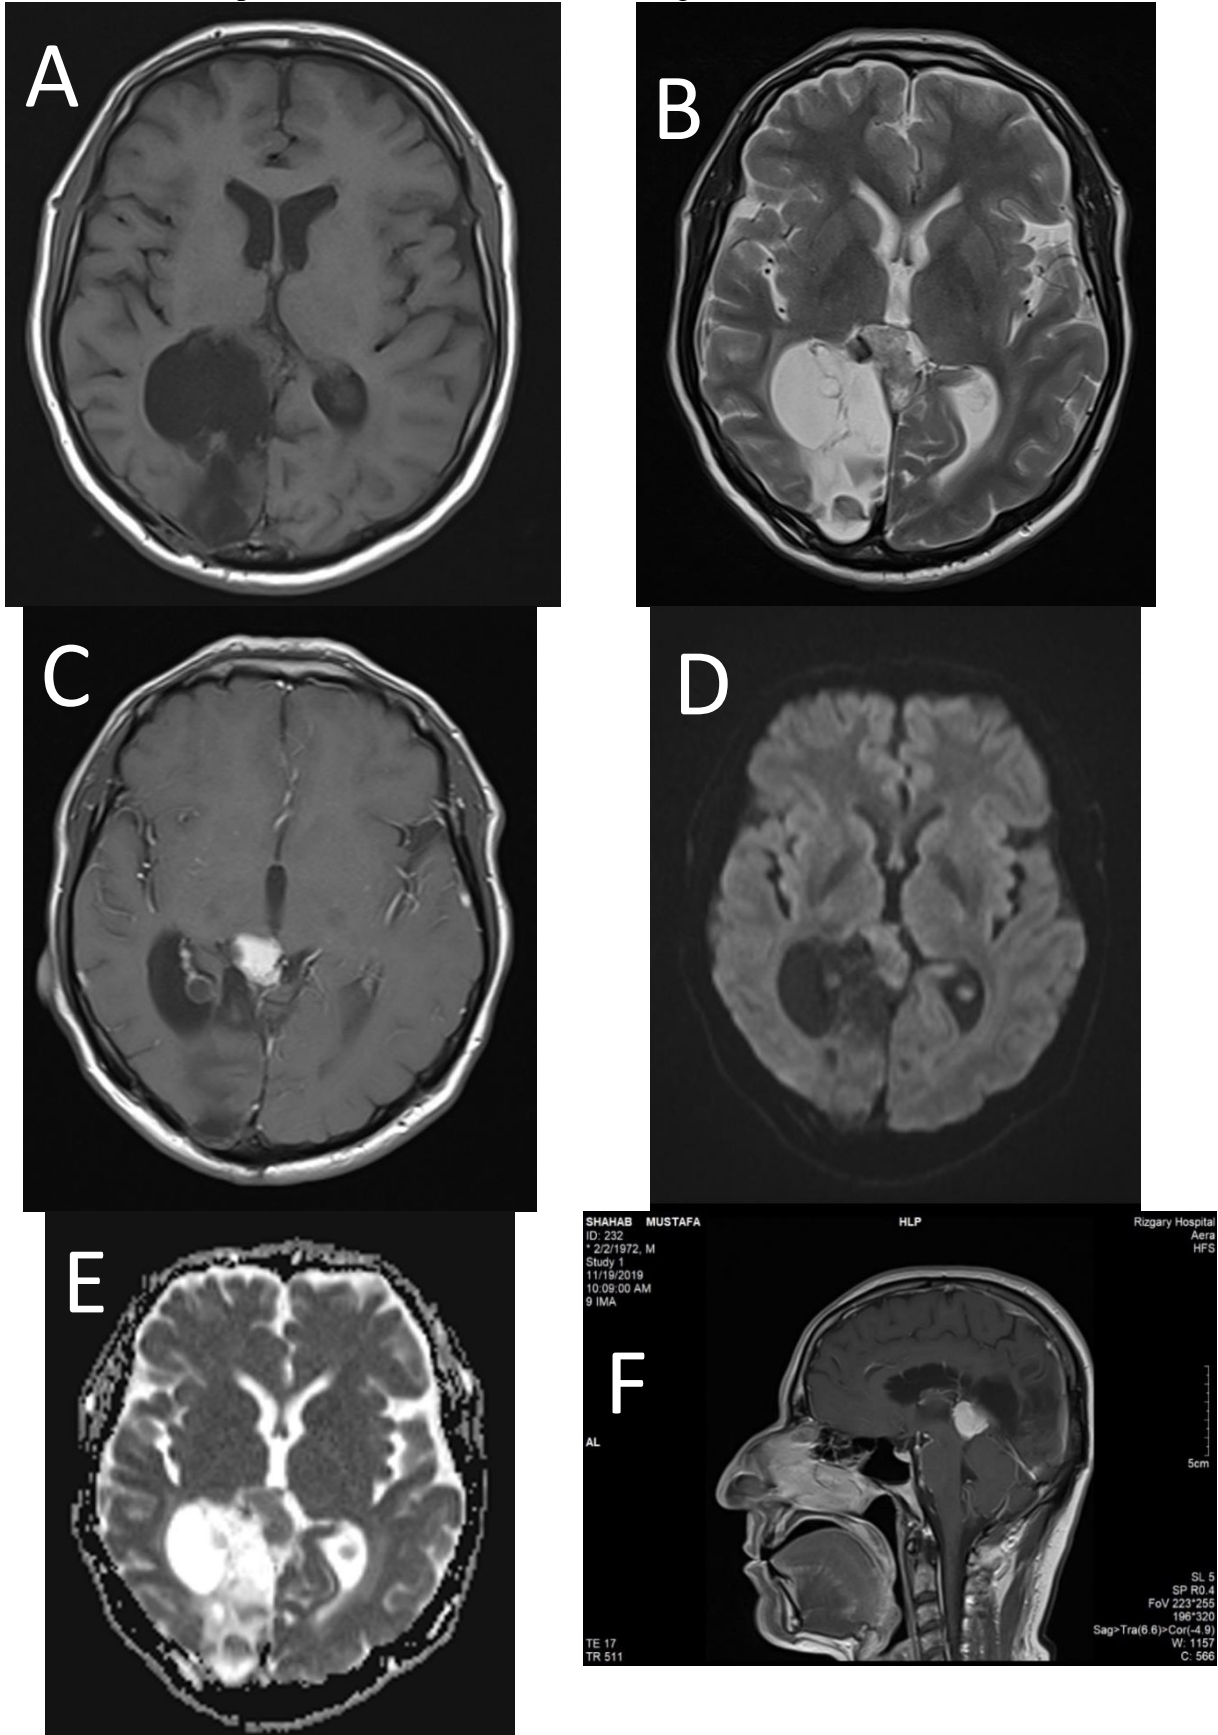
A 43 years old male with meningioma in the right quadrigeminal cistern with cerebromalacia seen in the right occipital lobe and evidence of occipital craniotomy, MRI shows isointense lesion in both T1-weighted (A) and T2-weighted images. (B) Post-contrast
